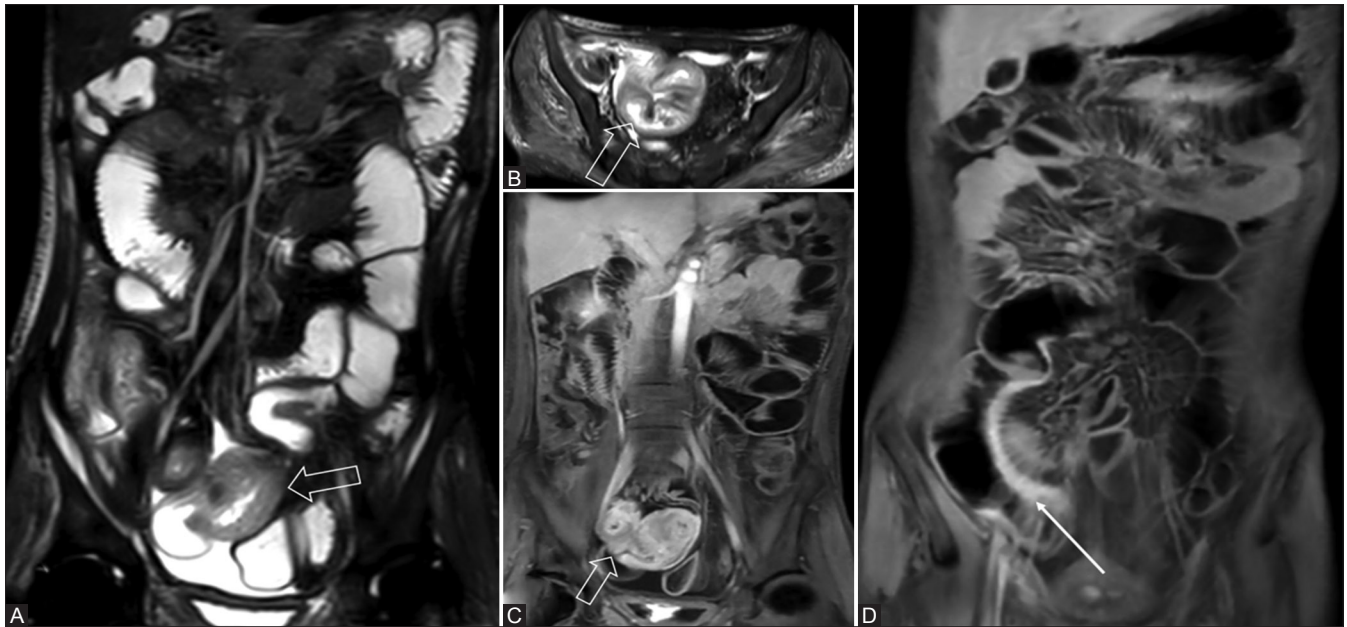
(A-D): Active CD. Coronal MRE (A) and axial T2-weighted images (B) showing segmental wall thickening of a pelvic ileal loop (outlined arrow) which shows T2 hyperintensity (A and B). Coronal postcontrast T1-weighted images (C and D) show stratified mural enhancement, asymmetrical wall thickening involving the mesenteric border of terminal ileum, with intense enhancement (thin arrow). These findings are typical for active inflammatory stage of CD
